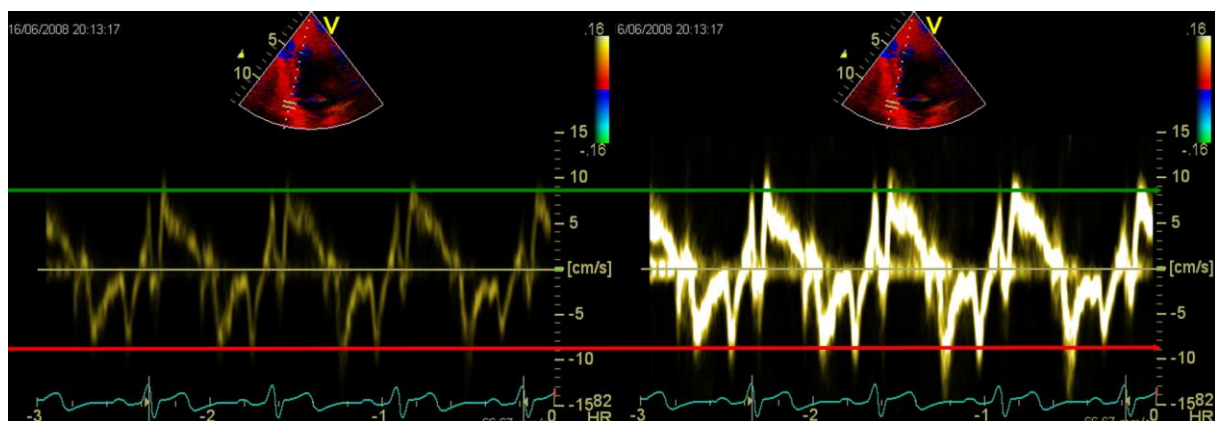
Pulsed wave spectral TD assessed velocities from the base of the inferior LV wall with low gain settings in the left recording and the high gain settings in the same recording at right. Green line refers to peak systolic velocity measured at the outer edge of the Doppler spectrum at low gain, and with high gain it is obvious that similar method measure higher velocity. Red line refers to peak early diastolic velocity at low gain, and similarly it looks like the velocities are higher when gain is increased.
